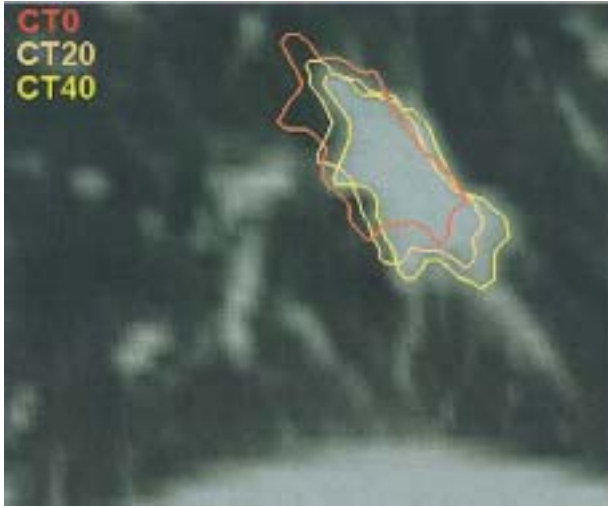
Tumor contours for 3 breathing phases. The contours labeled as CT20 and CT 40 were produced by applying the deformation field on the tumor contours delineated in CT0. The “trajectories” of the tumor boundary pictorially show the extent of tumor movement and allow us to specify patient specific margin in accounting for the intra-fraction organ motion.
